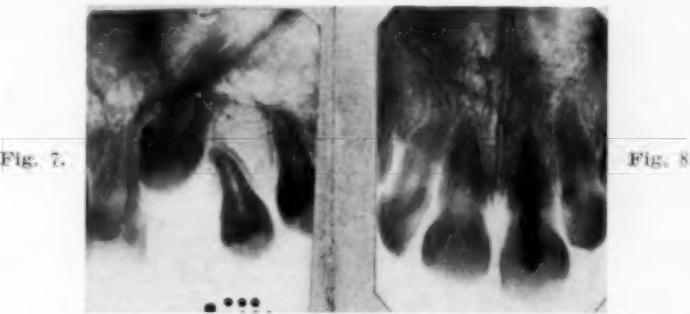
Roentgenogram of a fully formed cuspid in active eruption. The cuspid came into clinical occlusion about three years after the x-ray was taken. No orthodontic measures were used. (Courtesy of Dr. A. G. Brodie.)
